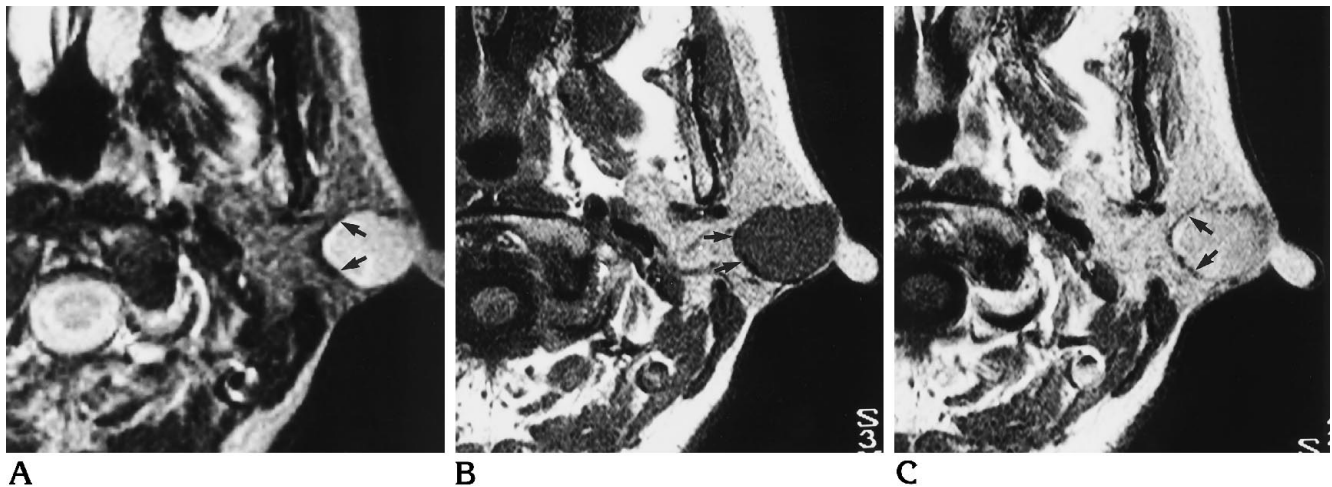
Pleomorphic adenoma in the superficial lobe of the left parotid gland. Axial T2-weighted (2000/80) (A), unenhanced T1-weighted (500/20) (B), and contrast-enhanced T1-weighted (500/20) (C) MR images show the tumor is surrounded by a capsule of low signal intensity (arrows) and has a lobulated contour on the T2-weighted image. The capsule is well seen on the contrast-enhanced image.
